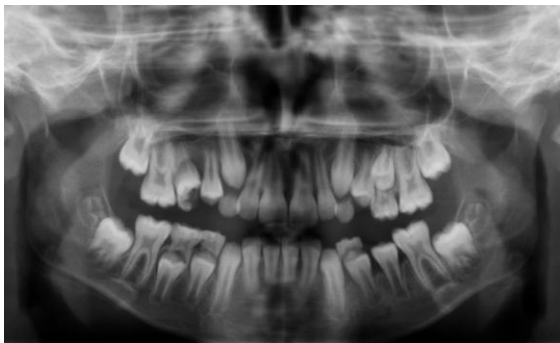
There were no distinctive radiologic manifestations of the lesion on left premolar region on panoramic radiography.
